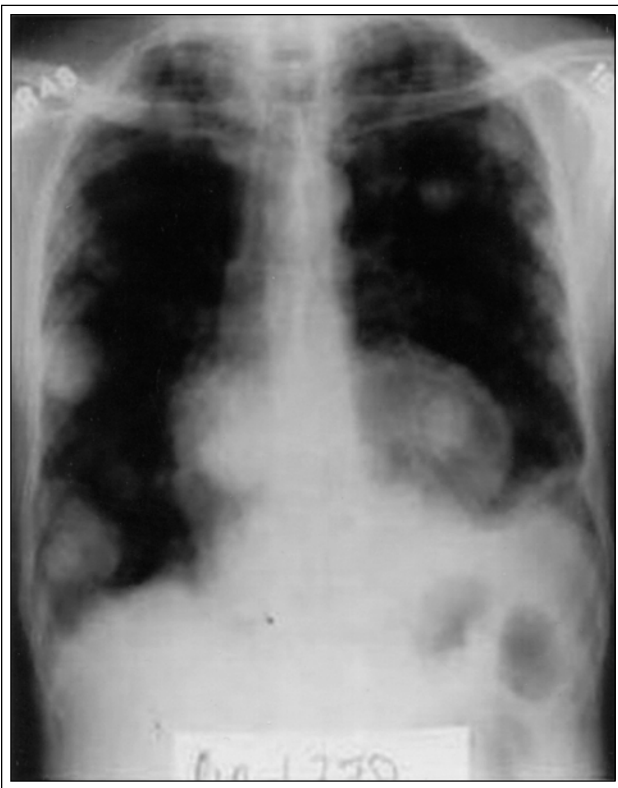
Chest X-ray showing bilateral pulmonary metastases.
